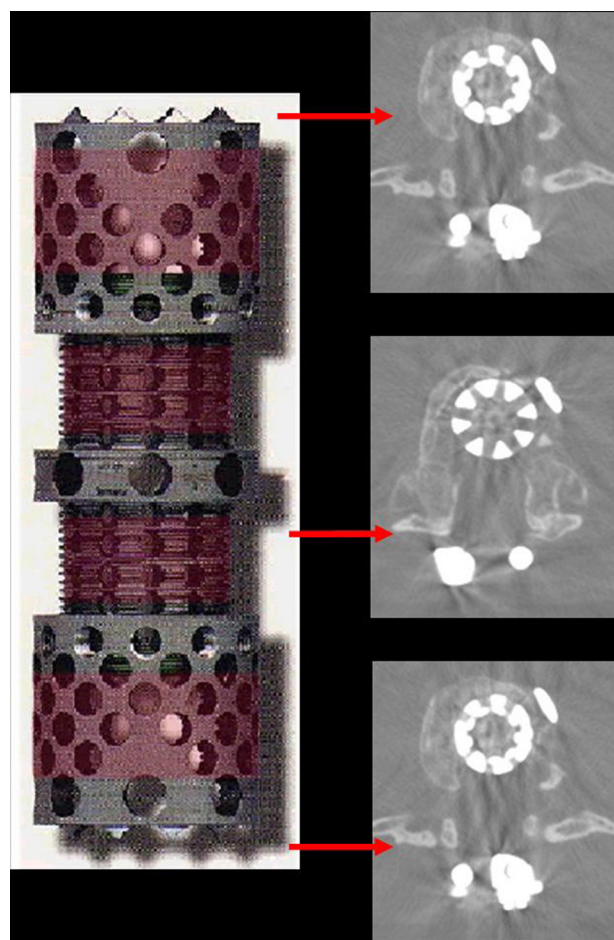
To evaluate progress of the bony fusion on CT-scan, three transverse images were selected; the first demonstrating the middle of the cage, while the other two were taken from the interface between the end of the cage and the cranial and caudal intact endplate respectively.
